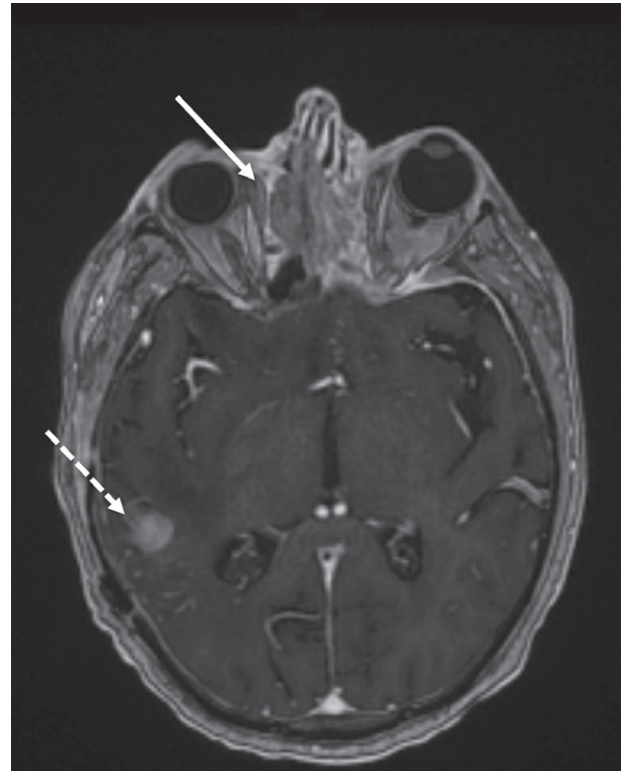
An MRI of the brain and sinuses in spoiled gradient (SPGR) post-contrast sequence again showing the left-sided abnormal soft tissue within the left ethmoid sinus with some mass effect on the left medial rectus muscle. Also imaged is abnormal soft tissue extending into the inferior aspect of the right orbit (solid white arrow) as well as a focus of intra-cerebral disease (dashed arrow).
